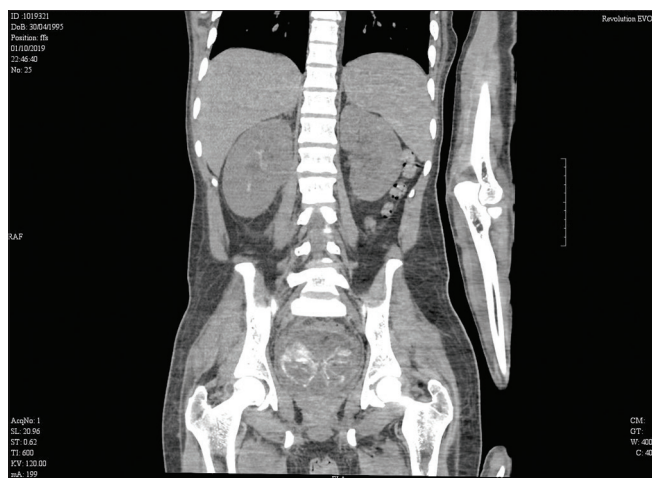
Noncontrast computed tomography showing full right pelvicalyceal system and full bladder with calcification (which we initially believed to be long-standing bladder clot with calcium deposit)
